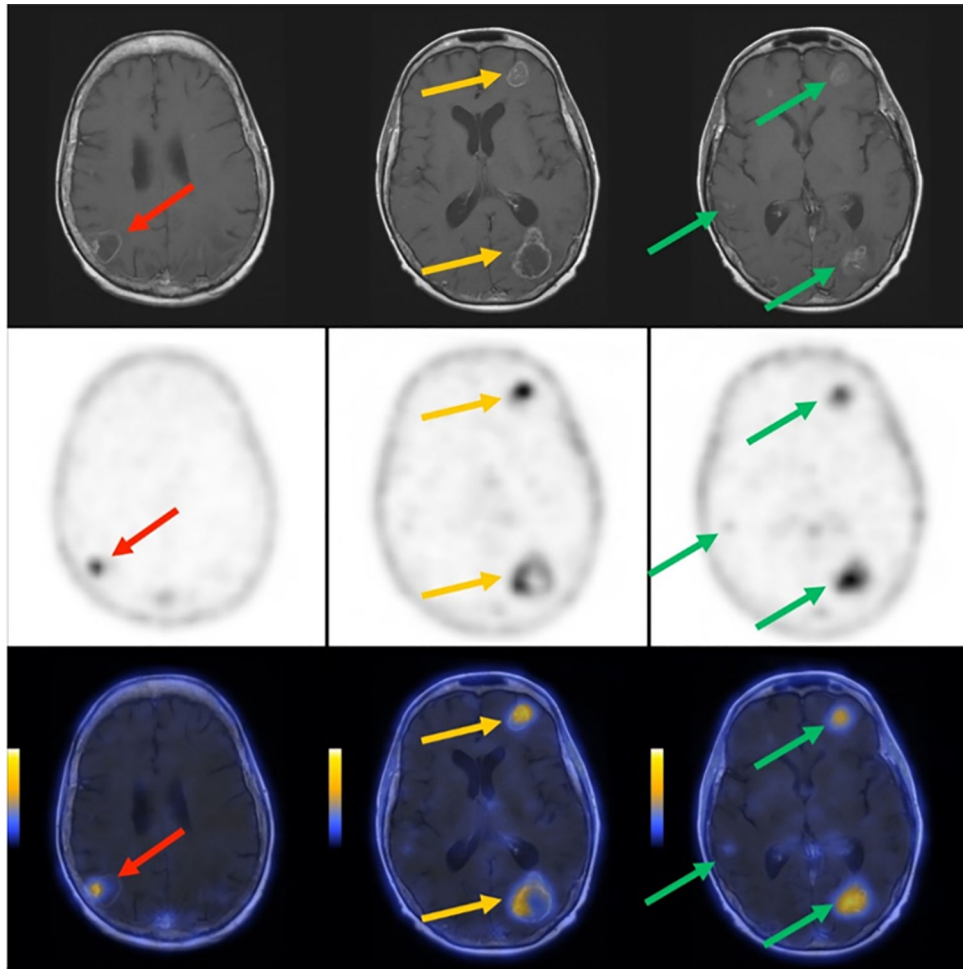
Representative MRI, PET, and PET/MRI images of brain for subject 3. Subject 3 was a 56 year old female diagnosed with moderately differentiated adenocarcinoma of the lung. Contrast enhanced T1-weighted MRI demonstrating multiple bilateral metastases (upper row). [^{18}F] $\alpha_v\beta_6$ -BP PET images of the brain 1 hour after intravenous administration [^{18}F] $\alpha_v\beta_6$ -BP demonstrating multi-focal elevated activity [scaled to $\text{SUV}_{\text{max}} 2.0$] (middle row). Co-registered fusion images of [^{18}F] $\alpha_v\beta_6$ -BP PET and MRI demonstrating PET activity matched to enhancing lesions [scaled to $\text{SUV}_{\text{max}} 2.0$] (lower row).
